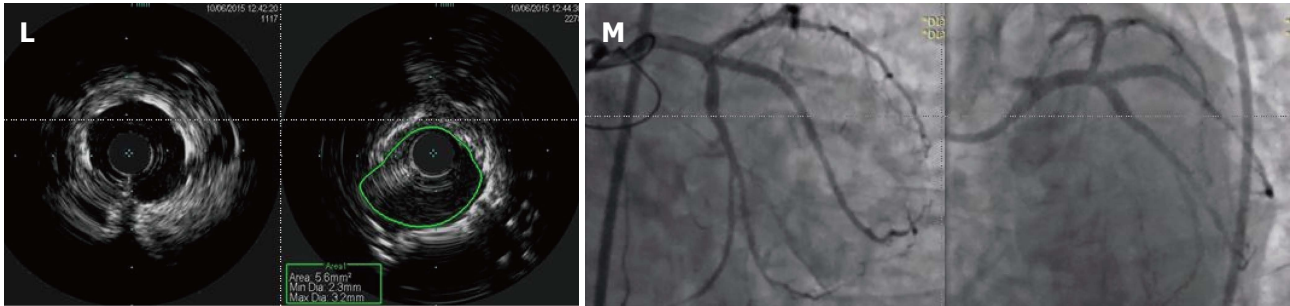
Sixty-seven-year-old man presented with increasing chest pain at rest. He has past medical history significant for coronary artery disease with PCI and coronary artery bypass grafting. He had PCI with (3.0 mm × 12 mm) DES to LCx, (2.5 mm × 16 mm) DES to RI and (2.5 mm × 16 mm) DES to obtuse marginal a year prior to his presentation. The left internal mammary artery to LAD is patent, however, he is known to have occluded SVG to RI and SVG to first diagonal (D1). Given his increasing chest pain, coronary angiogram was done. A: Coronary stents before contrast injection in LAD (red arrow), LCx (blue arrow); B: Coronary angiogram of the same patient showing severe proximal LCx ISR (blue arrow) with no flow, severe proximal RI ISR (green arrow) with slow flow, and mid LAD severe ISR (red arrow); C: Dilation of the RI coronary artery with 2.5 mm × 22 mm NC balloon with 22 atm inflation pressures was done; D: Coronary angiogram showing the proximal RI ISR (green arrow) post balloon dilation. Red arrow shows severe proximal LAD stenosis with poor flow. LCx has completely occluded ISR (blue arrow); E: The left circumflex ISR lesion (red arrow) was wired and with balloon dilation the flow was restored in the LCx (green arrow); F: IVUS imaging of the underexpanded stent in the proximal LCx lesion. Left panel shows stent struts (red arrow) with evidence of neointimal hyperplasia (yellow star). The right panel shows small stent CSA of only 3.6 mm² which is below the target 5 mm² in Asians and 6 mm² in non-Asians; G: IVUS imaging of the underexpanded stent in the proximal ramus coronary artery. Left panel shows severely under-expanded stent (red arrow) with evidence of neointimal hyperplasia (yellow star). The right panel shows small stent CSA of only 2.9 mm²; H: Excimer Laser Coronary Angioplasty treatment of LCx (left panel - red arrow) and ramus artery (right panel - green arrow) using 0.9 mm coronary laser and the heparinized flush technique. Laser catheter was advanced slowly at 0.2-0.5 m/s during laser emission with careful monitoring of heart rate and blood pressure. Vessel injury such as perforation, dissections and acute closure are the main side effects; I: Post laser balloon dilation with (3.5 mm × 20 mm) NC balloon of both LCx (red arrow) and ramus (green arrow) arteries; J: Sequential kissing stenting technique in the proximal LCx and ramus arteries with DES 3.5 mm × 18 mm in Ramus and 3.5 mm × 15 mm in LCx; K: IVUS imaging of the stent in the proximal LCx coronary artery that shows good expansion of the stent with great increase in CSA to 5.9 mm²; L: IVUS imaging of the stent in the proximal ramus coronary artery that shows good expansion of the stent with great increase in CSA to 5.6 mm²; M: TIMI III flow was achieved in the LCx and Ramus coronary arteries without any compromise of LAD. PCI: Percutaneous coronary intervention; DES: Drug-eluting stents; LCx: Left circumflex; RI: Ramus intermedius; LAD: Left anterior descending artery; SVG: Saphenous vein graft; ISR: In-stent restenosis; NC: Non-compliant; IVUS: Intravascular ultrasound; CSA: Cross-sectional area.
